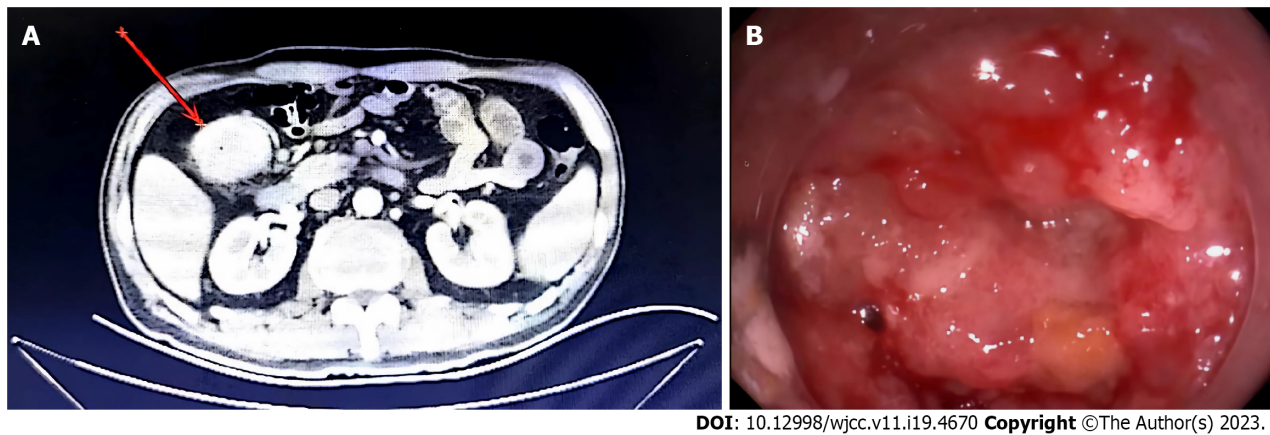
Initial X-ray and endoscopy findings. A: X-ray; B: Endoscopy. The patient’s tumor was located in the hepatic flexure of the right colon.
